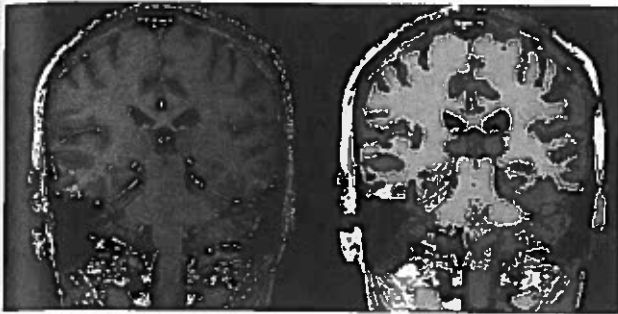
Modified adaptive clustering applied to a degraded MRI brain scan. Note symmetrical development of the cortex and of both hippocampi.
